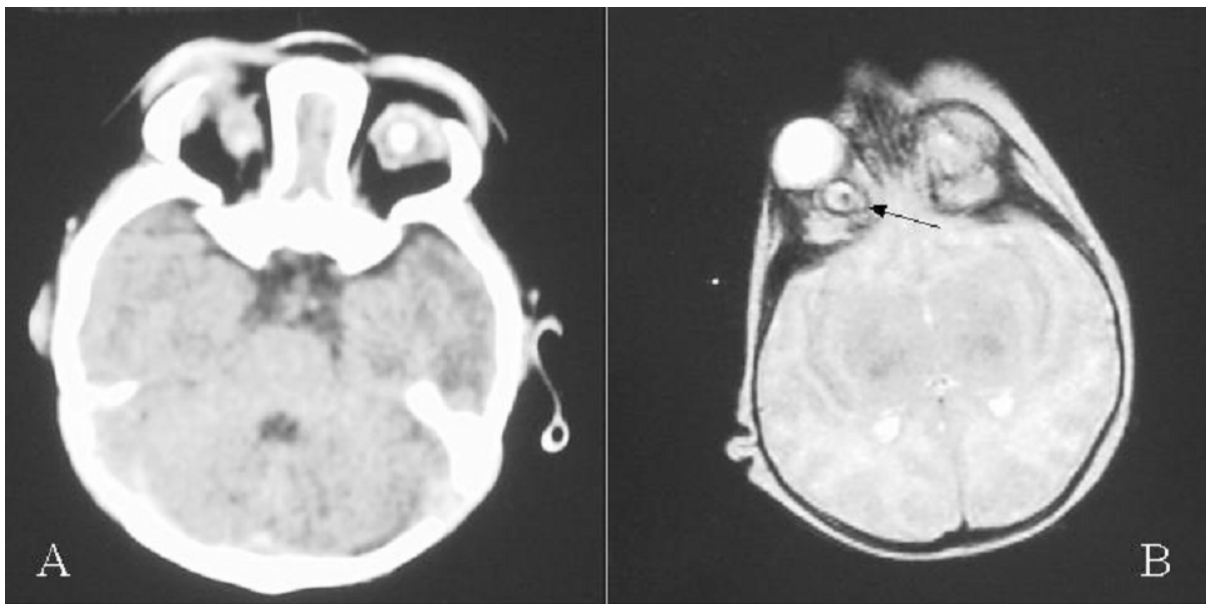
CT- (A) and MRI-scan (B) of the face and brain disclosing anophthalmia with cyst (arrow).
